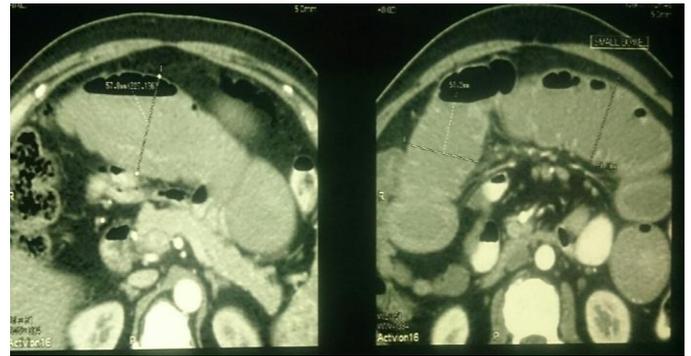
CT scan showing concentric wall thickening forming a mass in mid-ileum
